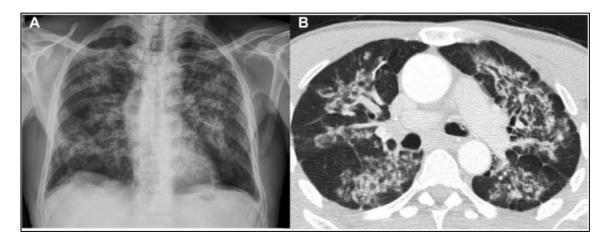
X-ray (A) and CT (B) showing confluent, reticular, and nodular irregular opacities confined to the central area of the lungs ("butterfly wing" pattern). Reproduced from: Rosa Junior et al.²
